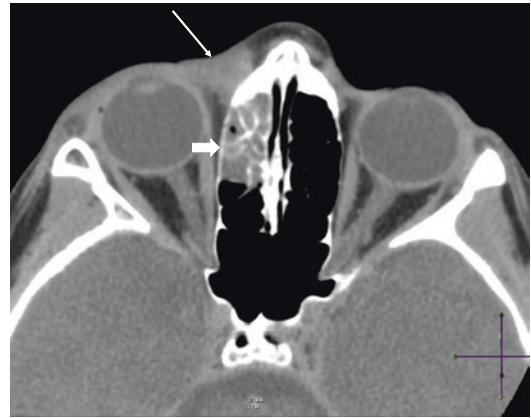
Axial CT soft tissue window showing opacification of the anterior ethmoid air cells (thick white arrow). Associated soft tissue swelling in the periorbital tissues (thin white arrow)
